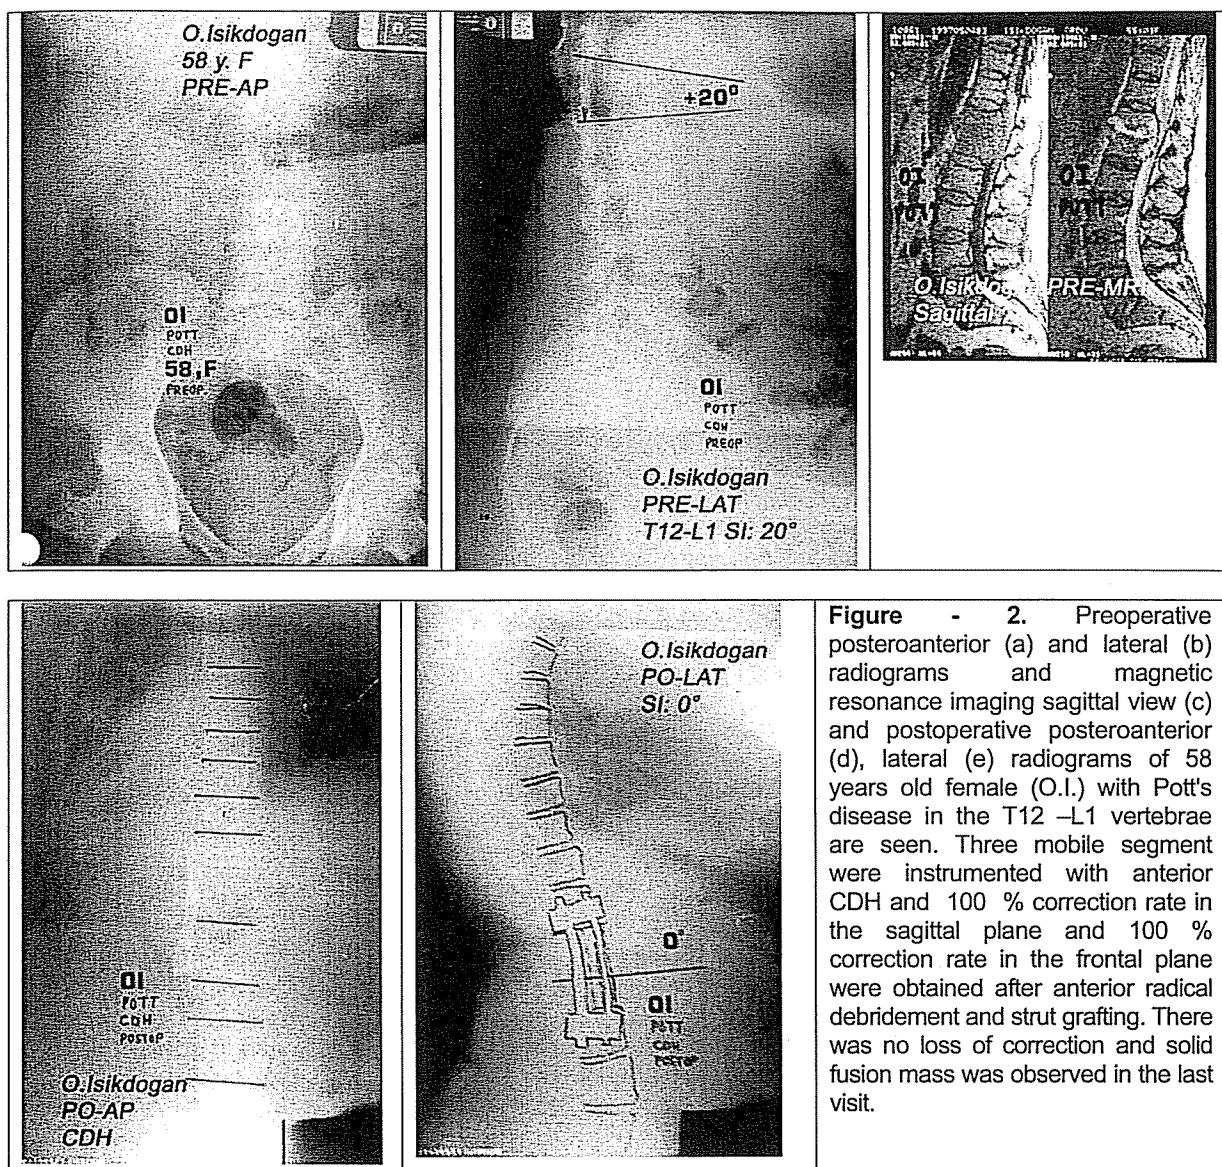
Preoperative posteroanterior (a) and lateral (b) radiographs and magnetic resonance imaging sagittal view (c) and postoperative posteroanterior (d), lateral (e) radiographs of 58 years old female (O.I.) with Pott's disease in the T12 –L1 vertebrae are seen. Three mobile segment were instrumented with anterior CDH and 100 % correction rate in the sagittal plane and 100 % correction rate in the frontal plane were obtained after anterior radical debridement and strut grafting. There was no loss of correction and solid fusion mass was observed in the last visit.
